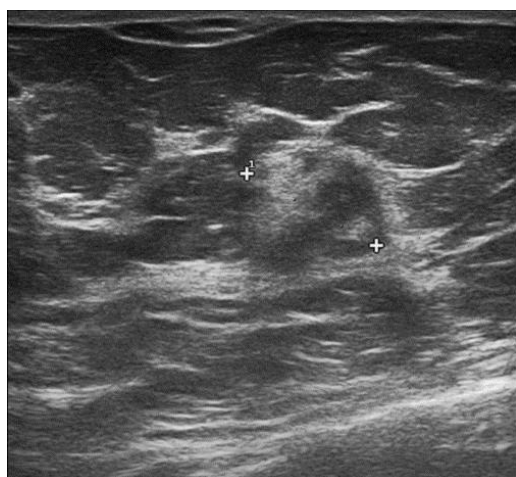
Ultrasound result of case (1).
